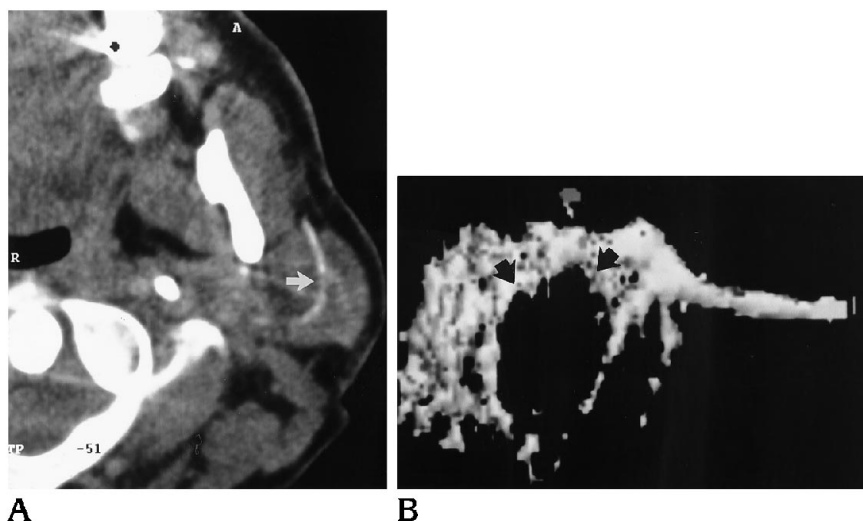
Cystadenolymphoma (Warthin tumor). A, Axial CT scan after sialography demonstrates displacement of the normal parotid parenchyma by tumor (*arrows*). B, Three-dimensional reconstruction (lateral view) shows the relationship of the tumor (*white arrow*), parotid tissue, and ductal system (*black arrow*).
